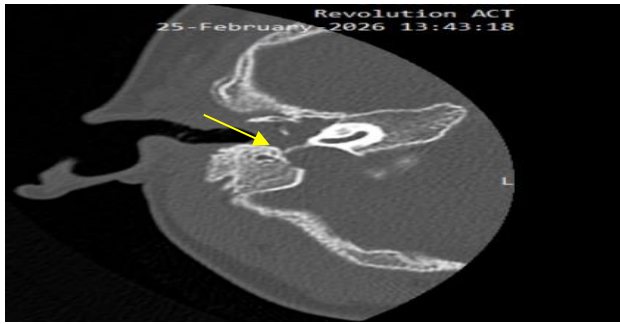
HRCT temporal bone in case four showing the presence of soft tissue in the right middle ear and mastoid (yellow arrow).
